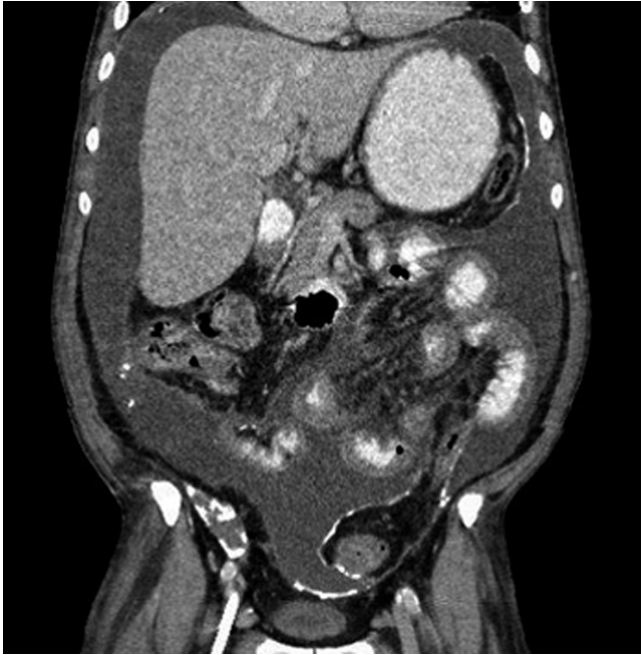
Coronal CT reconstruction in-patient with history of chronic renal disease. Multiple coarse peritoneal calcifications are identified secondary to retractile peritonitis.
